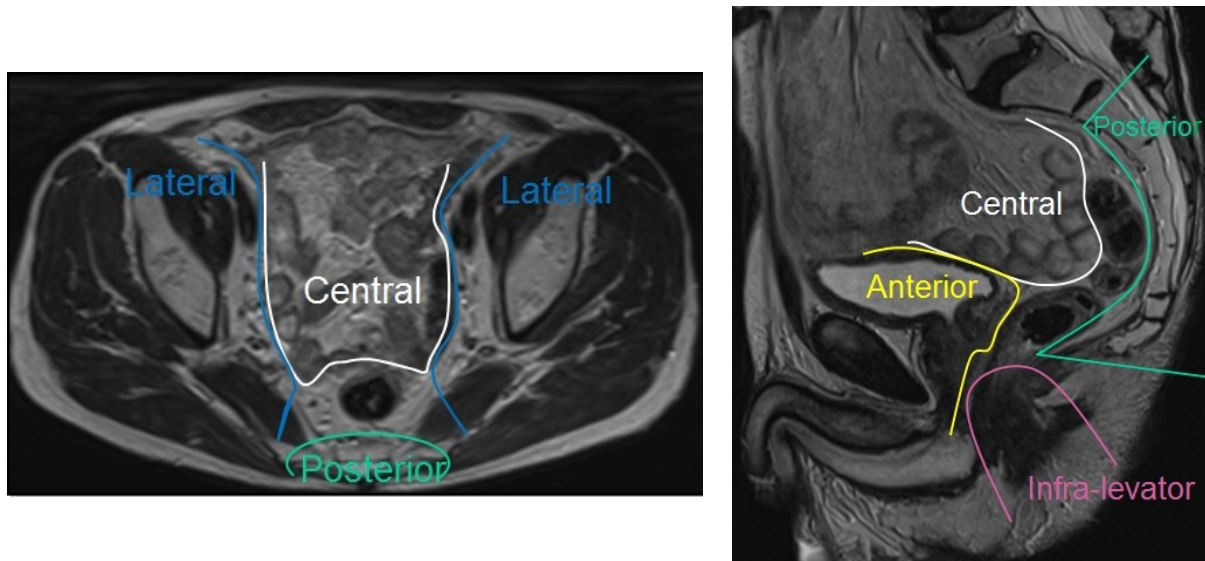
Compartmental staging of the pelvis on MRI for tumours which extend beyond the standard TME plane
